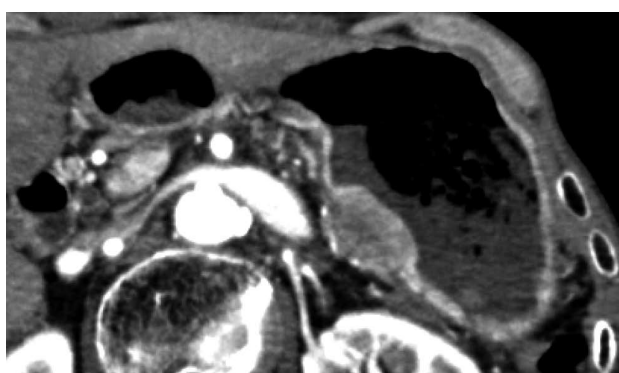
Computed tomography shows the submucosal tumor located adjacent to the pancreatic resection site.
